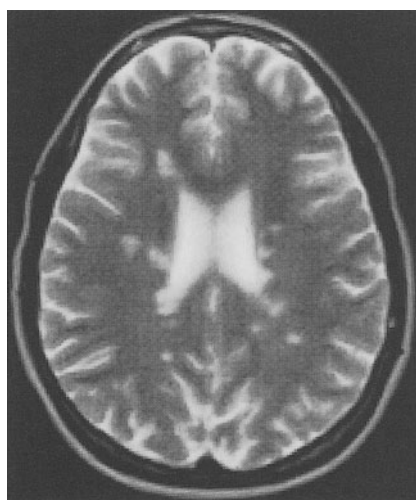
Axial T2-weighted MR (TR 5605, TE 117) of MS plaques from a 0.2-T Siemens open MR system. (Donald Schnapf, DO, York Imaging Center, Pennsylvania, used with permission)
